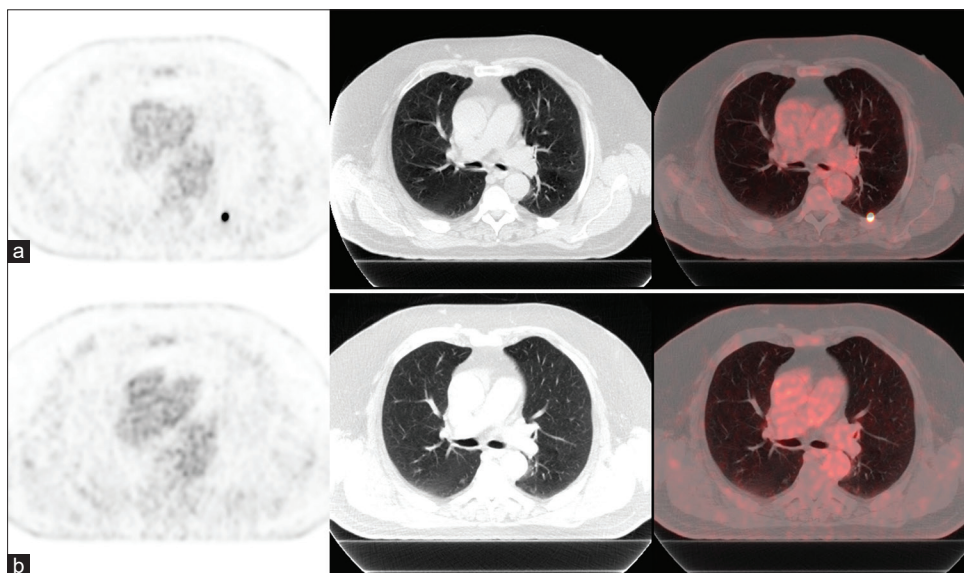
The ¹⁸F-fluorodeoxyglucose positron emission tomography/computed tomography and fusion positron emission tomography/computed tomography axial slices show a focal and intense ¹⁸F-fluorodeoxyglucose uptake ($SUV_{max} = 26.1$) located in the left lower lobe without anatomical alteration on computed tomography (a). The scan was repeated 2 weeks later and focal ¹⁸F-fluorodeoxyglucose uptake was resolved (b)
